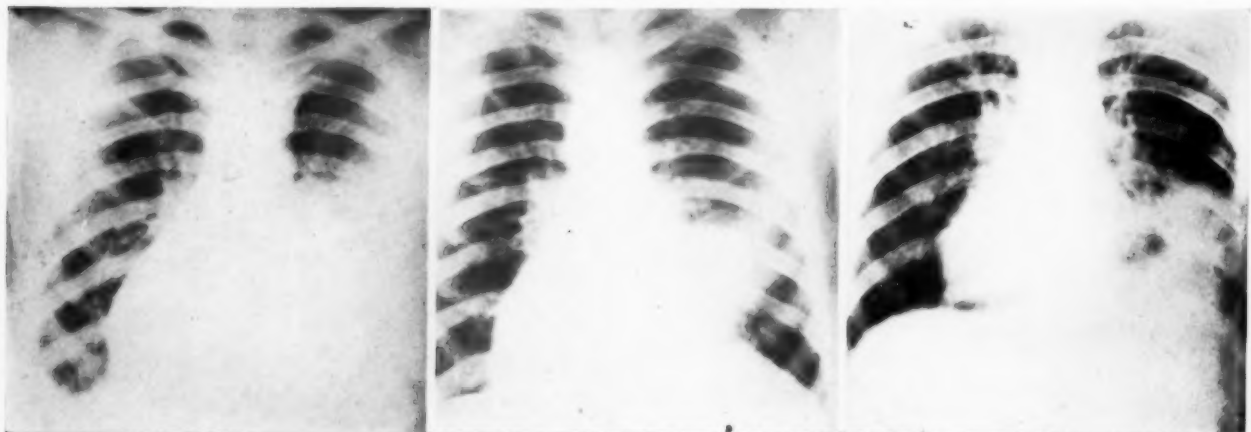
Idiopathic type of lung abscess. (a) Without apparent cause or reason the patient was seized with a chill, high temperature and pain in the chest. Radiographic examination at this time revealed a consolidation in the hilus region. (b) Within three days a definite abscess cavity was seen in the midst of the consolidation. (c) The consolidation increased rapidly in size. It is noteworthy that the abscess cavity previously seen was no longer discernible.
